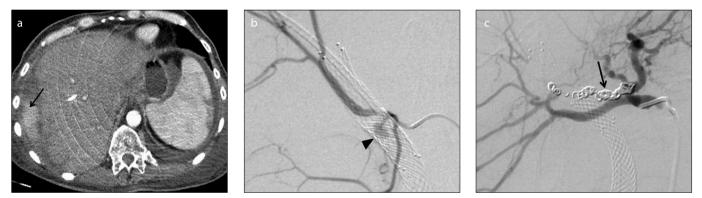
a-c. Axial computed tomography angiography image (a) of a 48-year-old male patient, who had undergone percutaneous transhepatic biliary drainage because of icterus due to primary liver lymphoma, shows perihepatic hematoma and extravasation (*arrow*). Superselective angiography image (b) shows a pseudoaneurysm (*arrowhead*) of the middle hepatic artery that occurred five days after biliary drainage and stenting. The parent artery was embolized in this patient, because embolization of only the pseudoaneurysm sac may have led to the recurrence of hemorrhage. Control angiography (c) reveals total embolization with pushable coils (*arrow*).
